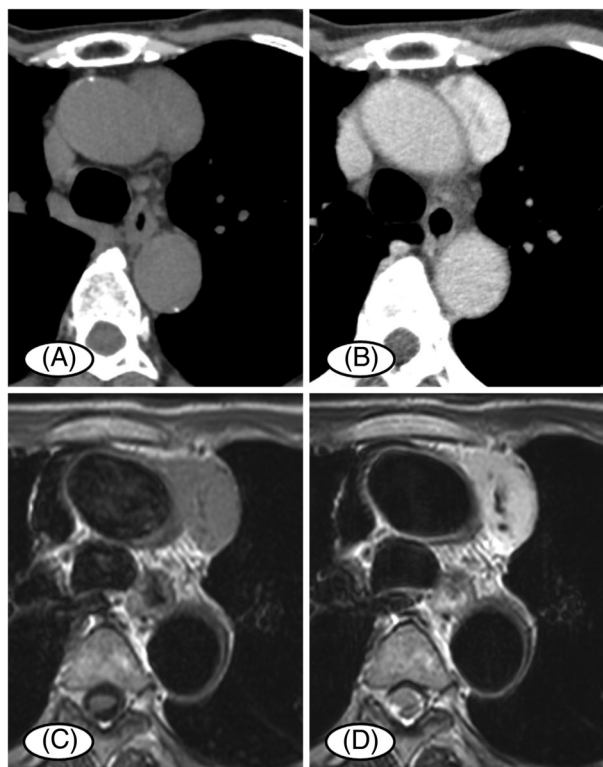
Imaging findings. (A) Simple CT showing a 4.0×3.5 cm tumour in the anterior mediastinum. (B) Contrast-enhanced CT shows no traffic with surrounding vessels. (C), (D) MRI showed low intensity on T1-weighted images and high intensity on T2-weighted images
